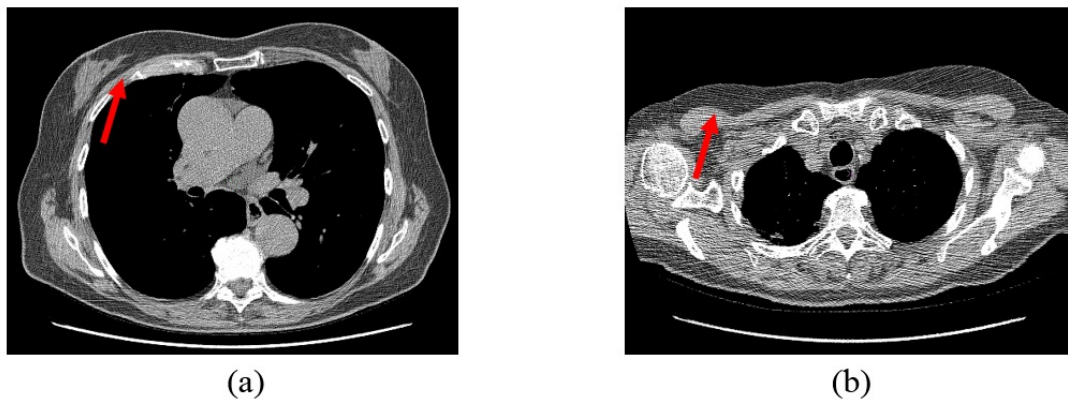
Axial CT slices at (a) the median level of the breast and at (b) the level superior to the sternal angle. The arrows indicate significant variations in terms of the shape and dimensions of muscles at these two axial levels.
